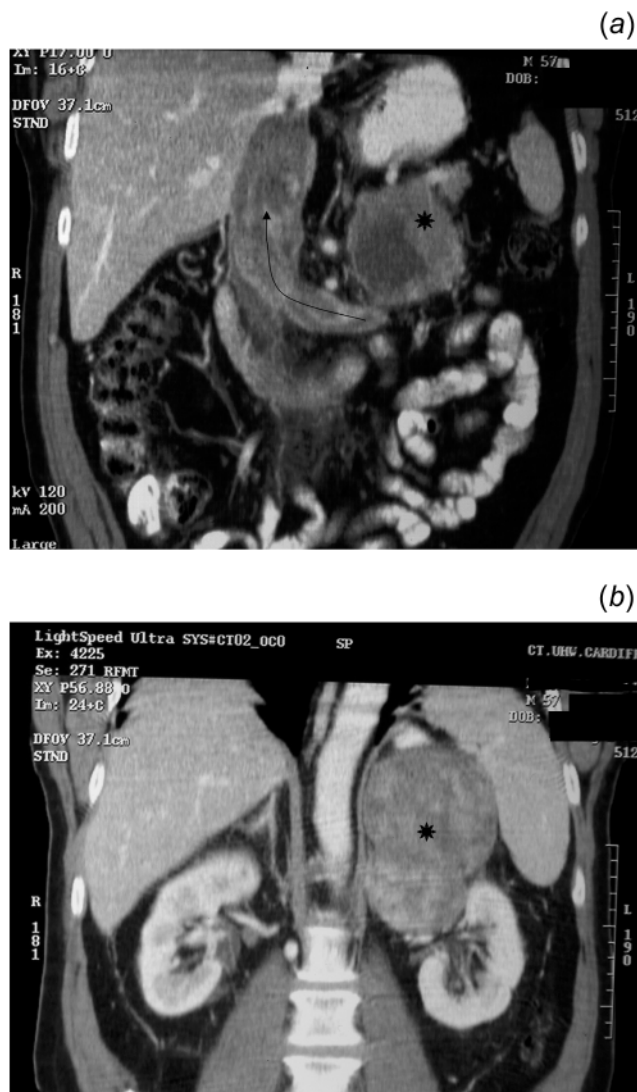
Coronal reconstructions of CT scans. (a) tumour thrombus is seen extending from left renal vein to inferior vena cava (arrow); \* = left adrenal tumour. (b) \* = left adrenal tumour
